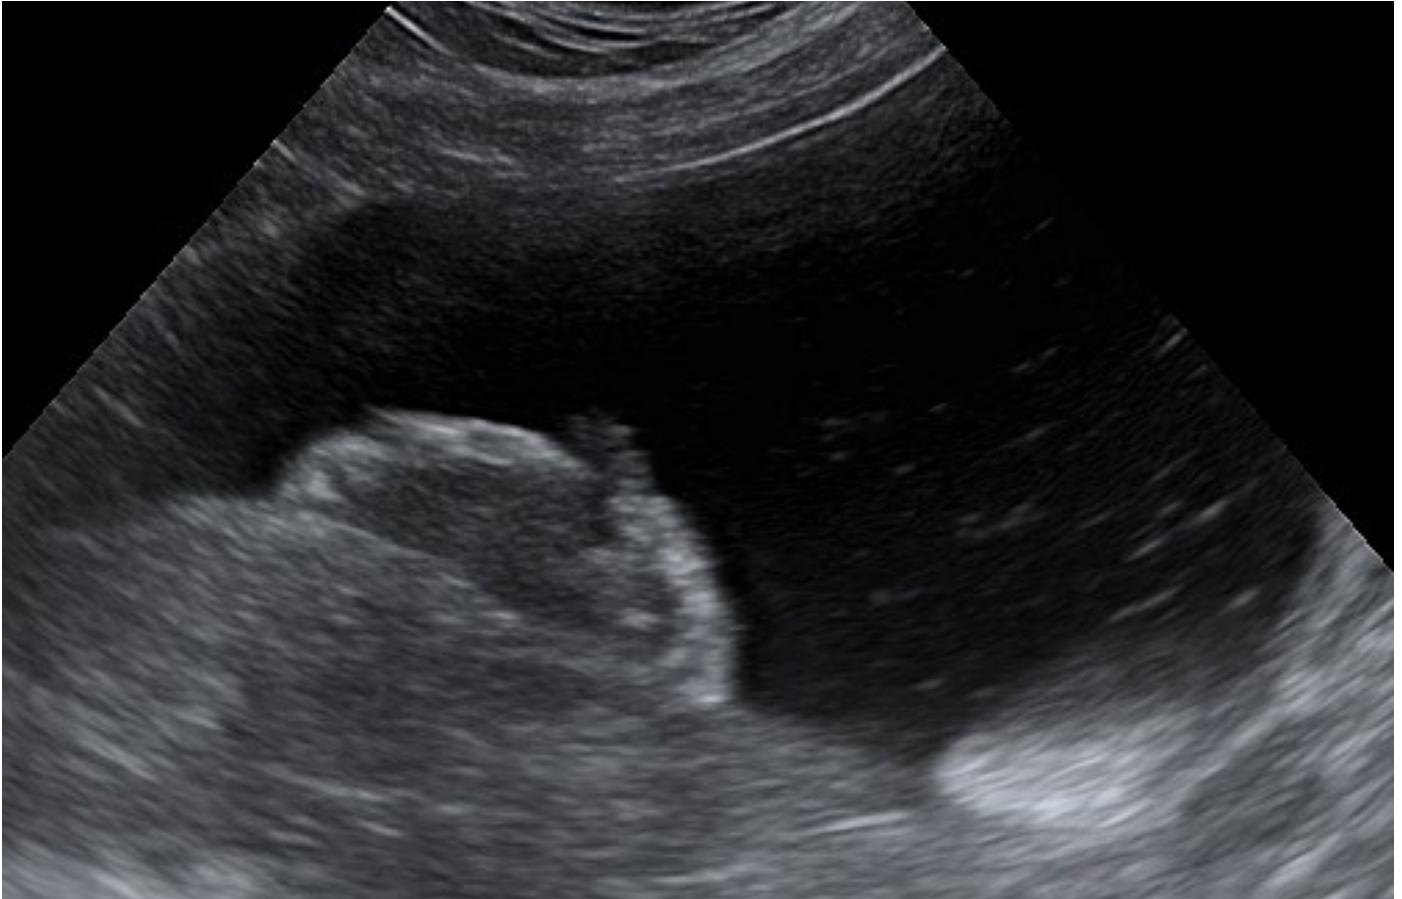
Ultrasound image of a urinary bladder carcinoma
